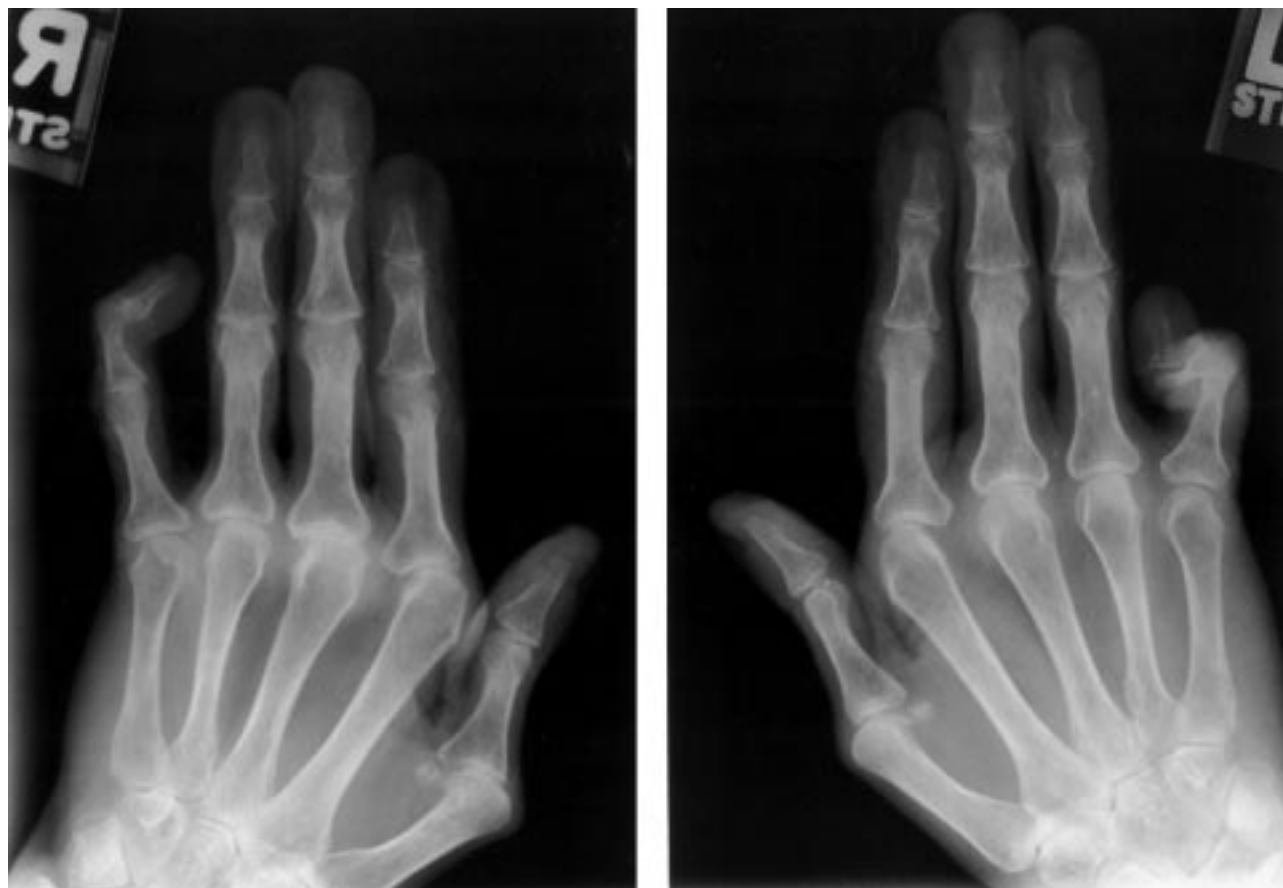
Hand radiographs taken November 1997. Despite previous surgical correction of boutonniere and swan neck deformities (1979), there is swan neck deformity of the left 5th digit and a flexion deformity of the right 5th digit. There is no evident cartilage erosion of the joints. The findings are consistent with the diagnosis of Jaccoud's arthropathy.
